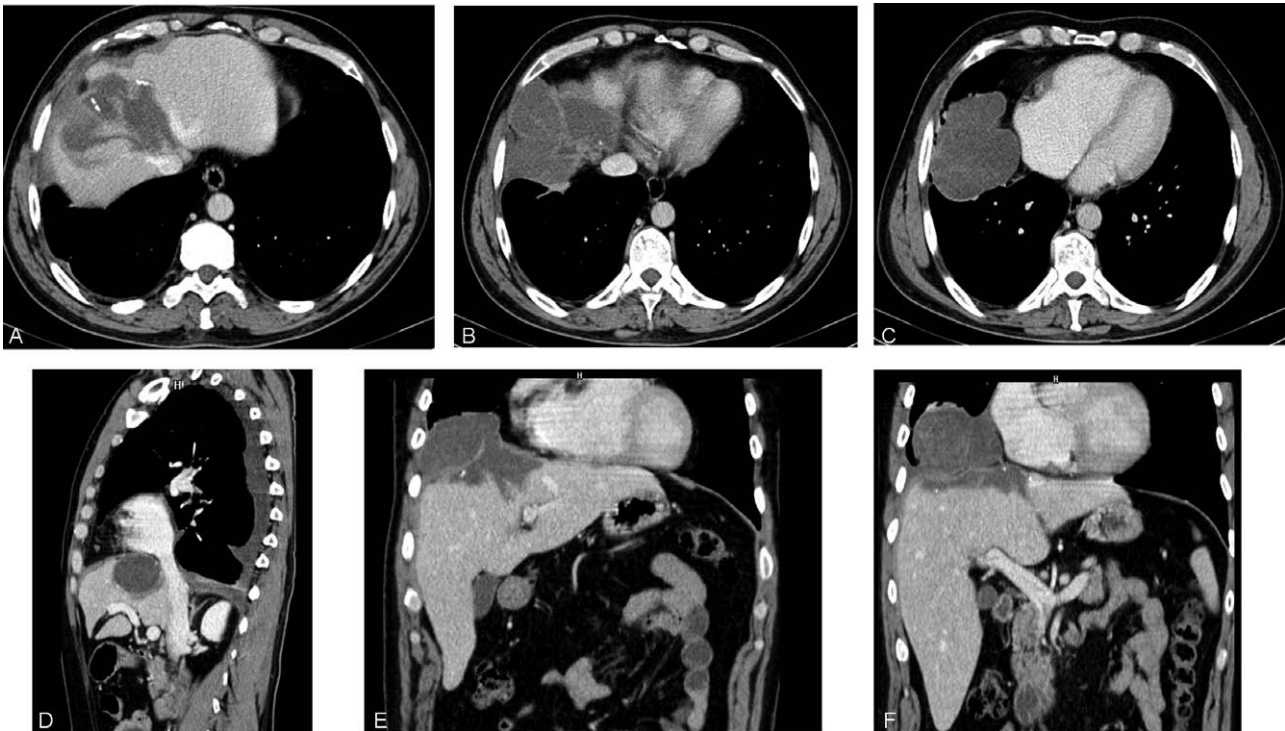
CT scan showing multiloculate hydatid cysts of the right hepatic lobe abutting the diaphragm and involving the lower pulmonary right lobe in a 44-year-old man. He underwent radical pericystectomy associated to diaphragm repair, and lower pulmonary lobectomy (A–C: CT axial view; D: CT lateral view; E and F: coronal view).
